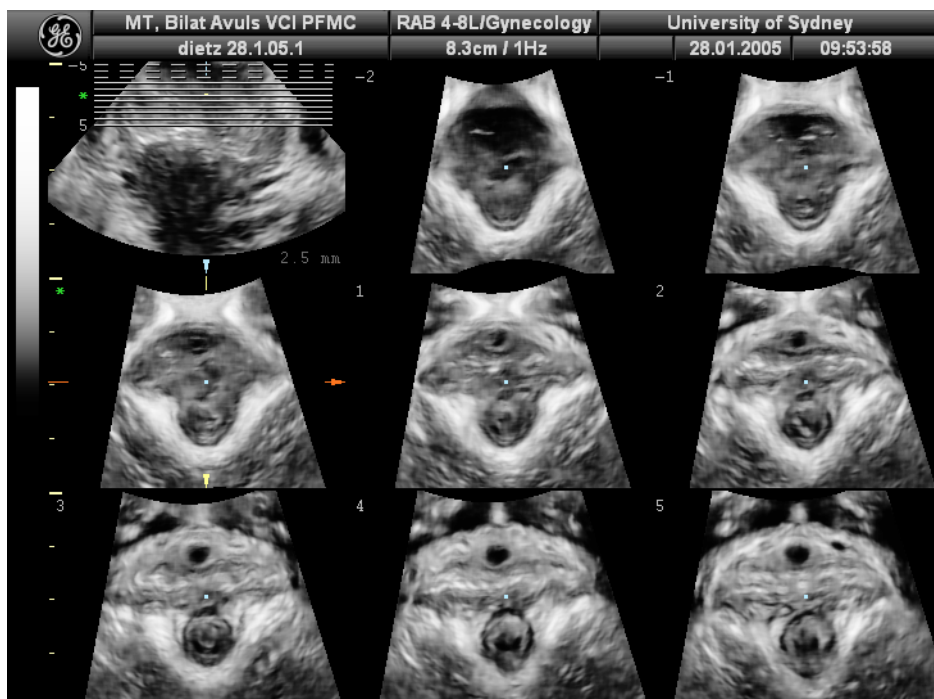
Tomographic ultrasound imaging of a bilateral avulsion injury in a stress incontinent 42 yr old p3 (rotational Forceps delivery for 1st child). The defect score in this patient is 8+8= 16.
